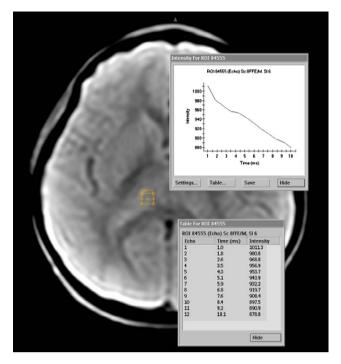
Axial MRI image at the level of basal ganglia and thalami. Region of interest (ROI) is drawn on right thalamus to derive the T2* signal intensity decay curve.
